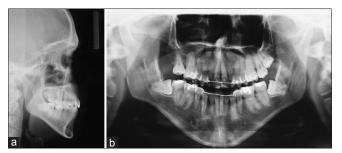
(a) Teleradiography, (b) orthopantomography
